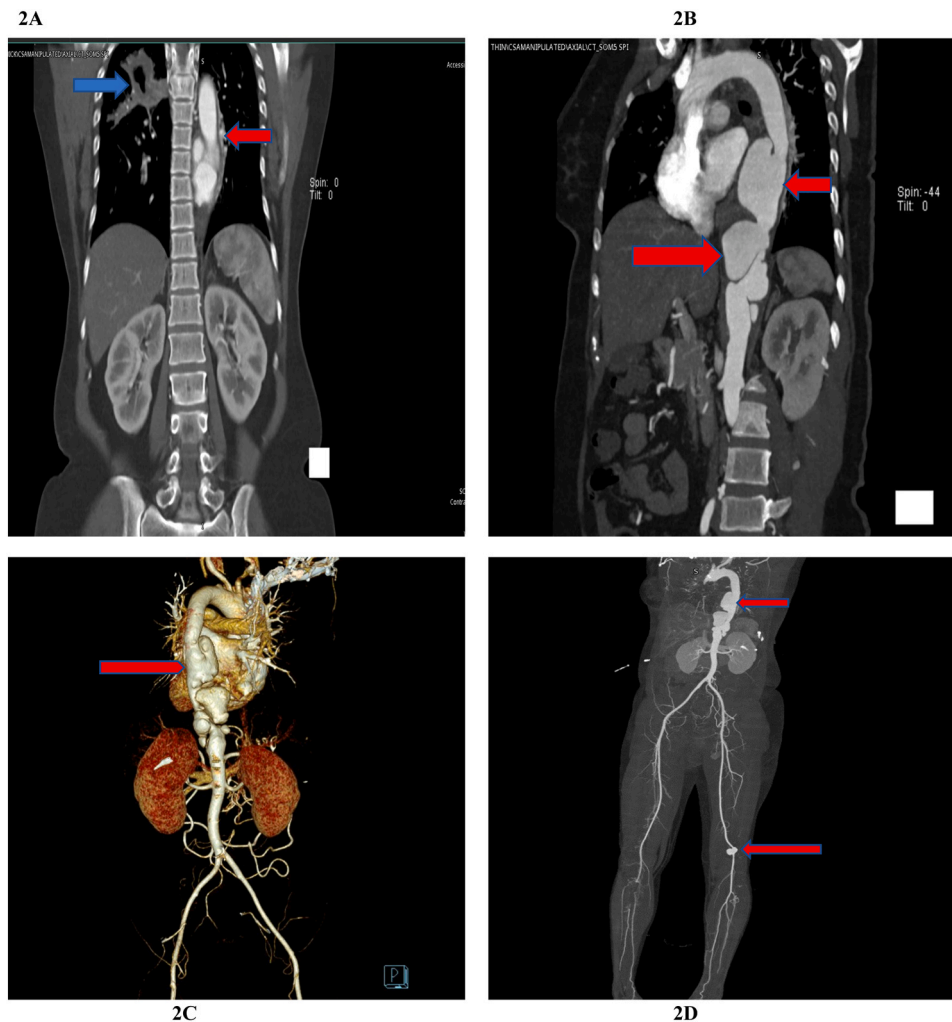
A–D: CT angiography and PET scan demonstrating huge multiple aneurysmal dilatation in the descending aorta and left popliteal artery (red arrow). Also, obvious right-side chest cavitation can be seen on A in the same view (blue arrow).
